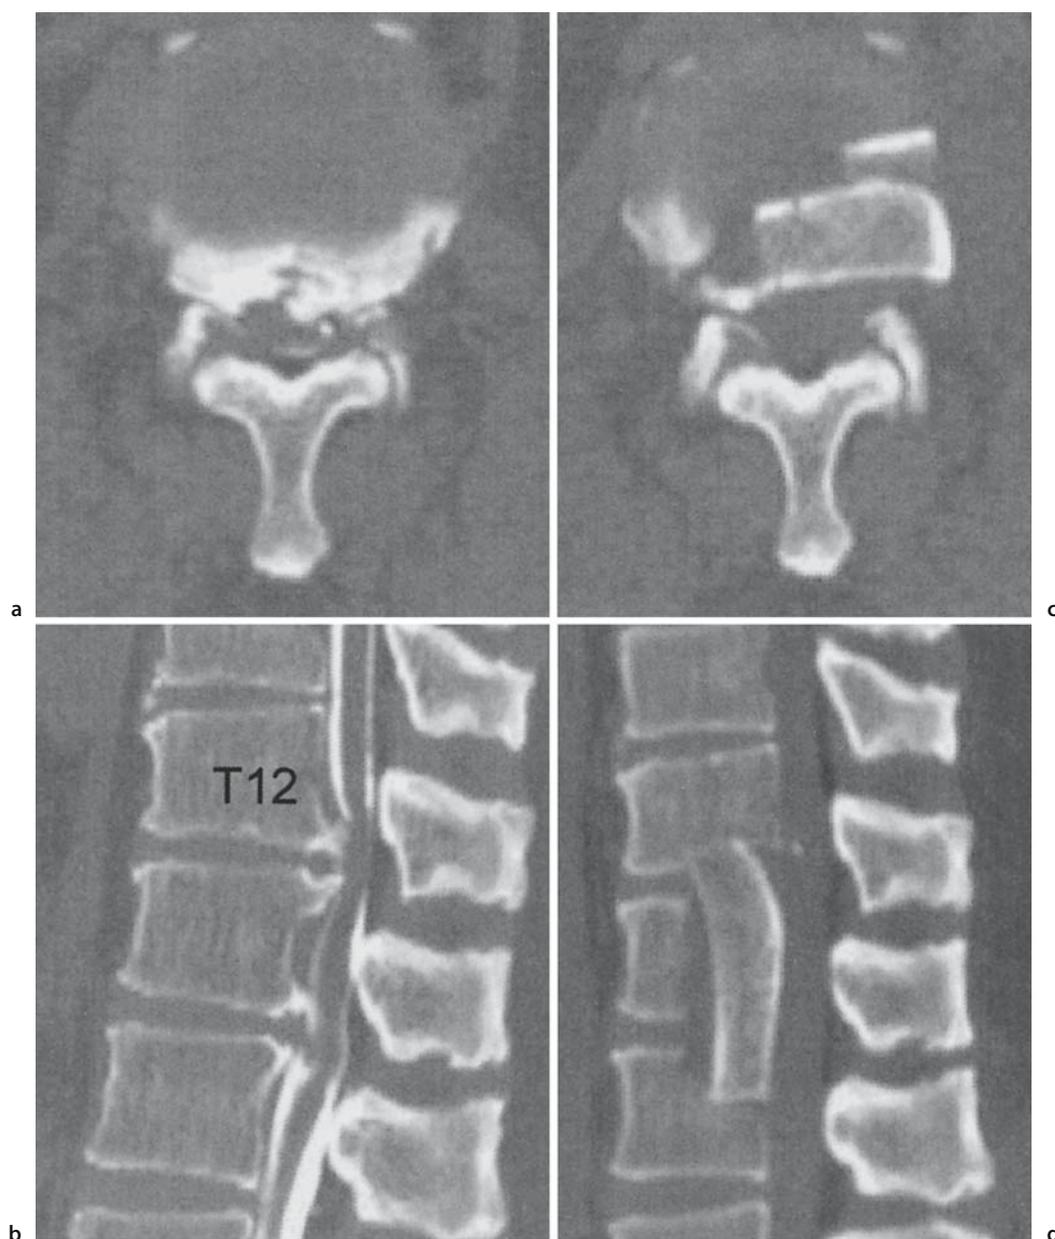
Anterior decompression and fusion. Preoperative and postoperative magnetic resonance imaging (MRI) and computed tomography (CT) of a 54 year-old man with OPLL between T12 and L2. a, b Axial and reconstructed CT revealing
